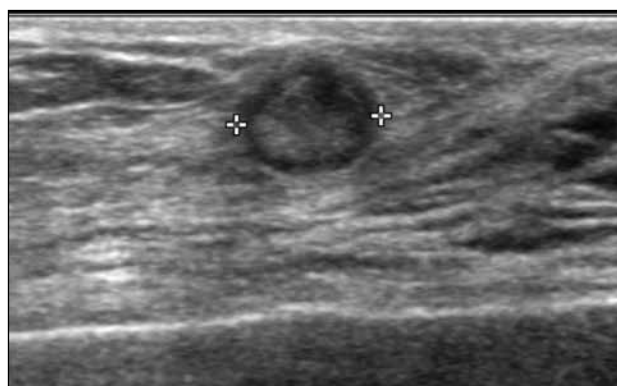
An 82-year-old woman with a palpable right breast nodule. Ultrasonogram showing a predominantly hyperechoic oval circumscribed lesion with thin hypoechoic rim. Biopsy showed apocrine metaplasia.
